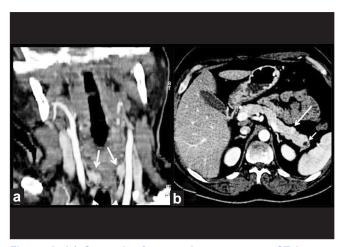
(a) Coronal reformatted post-contrast CT images showing homogenously enhancing enlarged bilateral superior and inferior parathyroid glands (arrows). (b) Post-contrast axial abdominal CT scan showing homogenously enhancing small lesion in the tail of the pancreas (big arrow) and non-enhancing cystic lesion in the tail of pancreas (small arrow)
